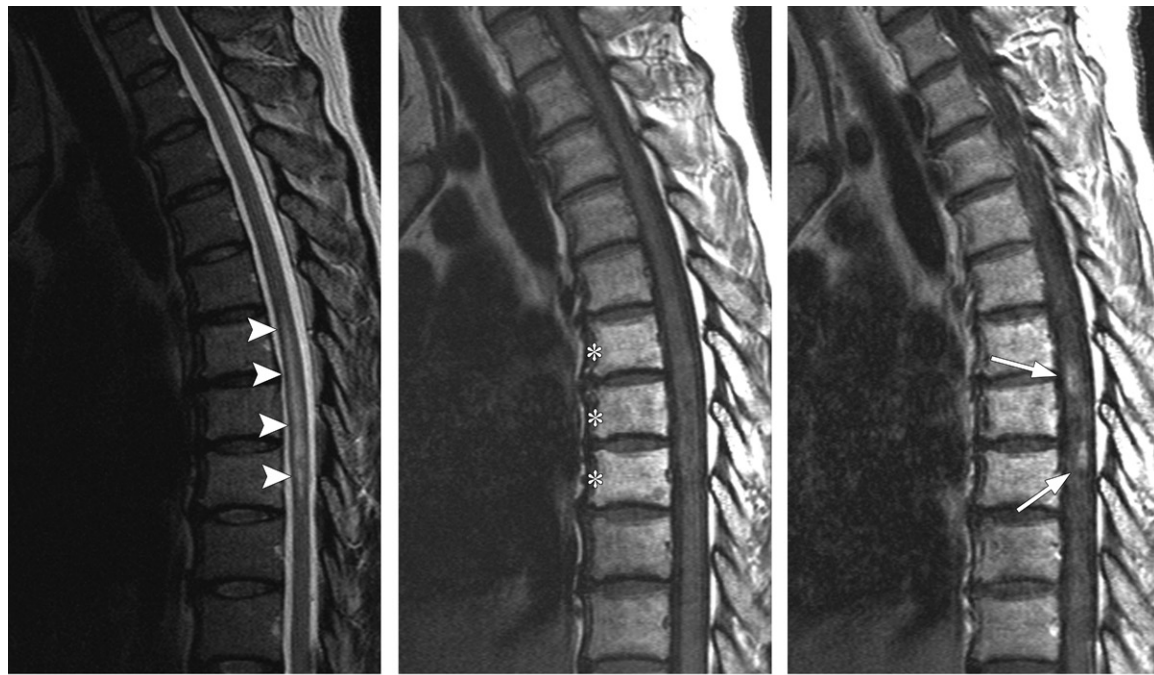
Myelitis and fatty marrow changes in a 48-year-old woman with lower extremity weakness and paresthesia. She underwent RT (standard-fractionation type) 3 years earlier for a metastasis from lung cancer to T7. (a) Sagittal T2-weighted image shows longitudinal extensive myelitis as hyperintense signal changes (arrowheads). (b) Sagittal T1-weighted image shows fatty marrow changes of T5–T7 (*). (c) Sagittal contrast-enhanced T1-weighted image shows the myelitis seen in a as partial enhancement (arrows).
